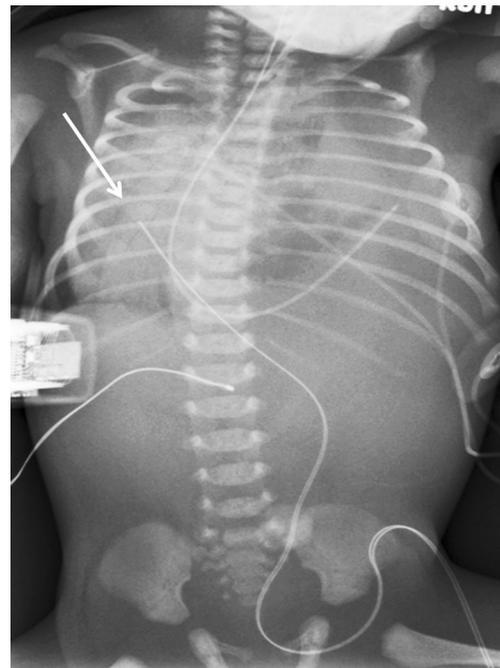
Anteroposterior radiograph of the chest and abdomen in a newborn boy shows the correct placement of a UVC (umbilical venous catheter) (*arrow*), which courses toward the right in this boy with left congenital diaphragmatic hernia and is overlying the expected region of the rightward deviated inferior cavoatrial junction
